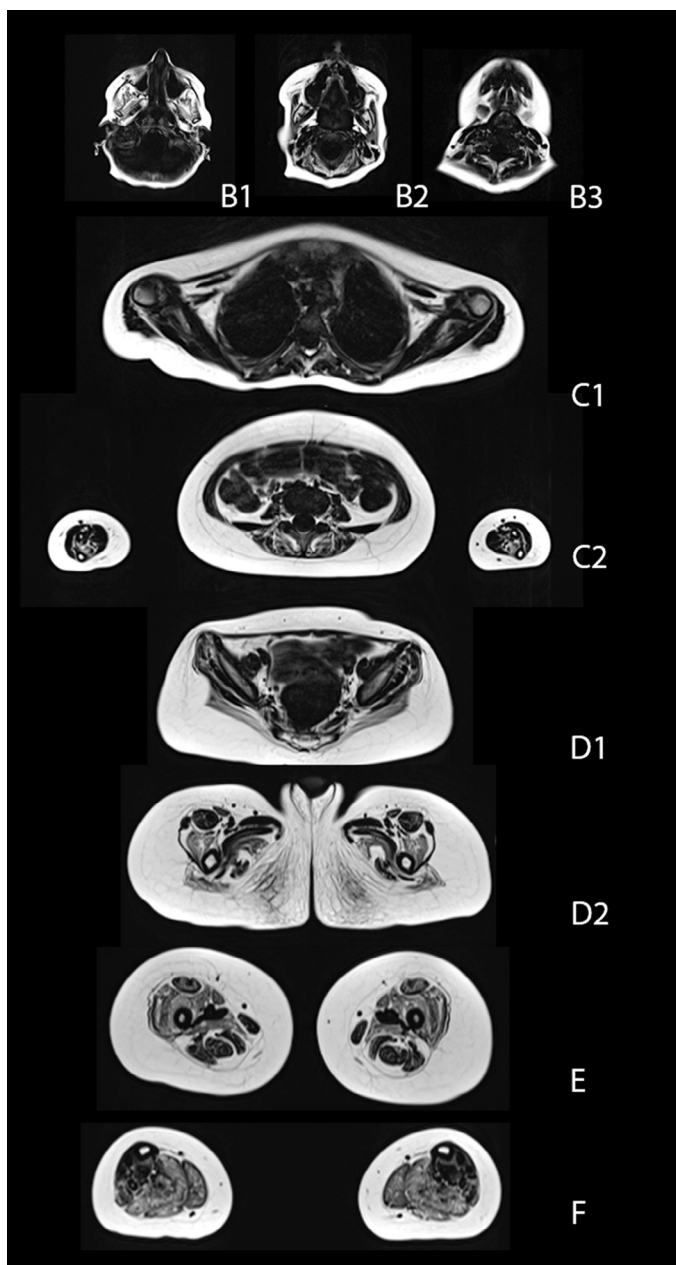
Whole body MRI of the assessed muscles. Axial T1-weighted Dixon Fat-only images of the different regions of the body from top to bottom: head, neck, shoulder girdle, trunk and forearms, pelvic girdle, tight, and legs (see also [Supplementary Fig. S2b](#) for corresponding scanning positions and order).
